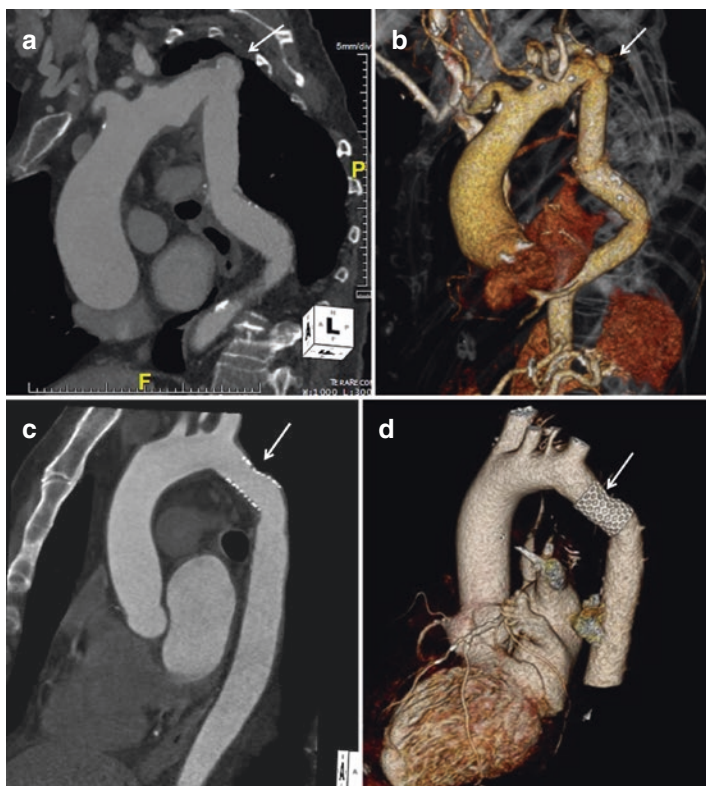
CTA for aortic coarctation. Oblique reformatted (a; candy cane view) and volume rendered (b) images show a sacular aneurysm arising from the proximal descending thoracic aorta at the site of coarctation repair. Similar CTA reconstructions a patient treated with angioplasty and stenting show a patent stent lumen without any evidence of stent fracture (c, d)
